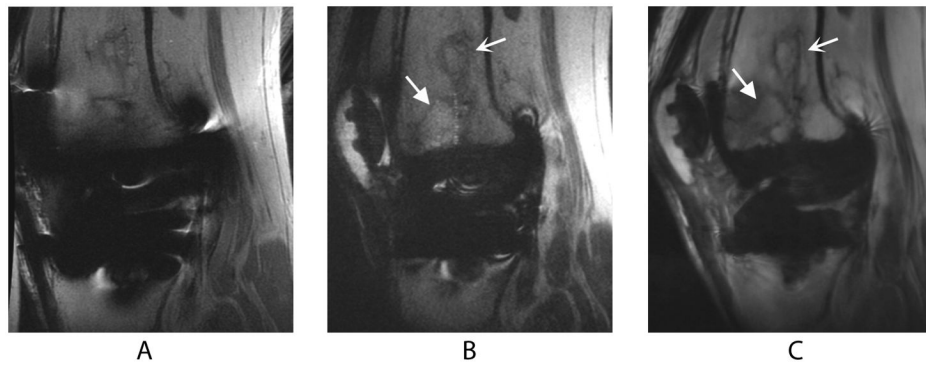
Sagittal images of a TKR produced by FSE (a), SEMAC (b), and MAVRIC (c) MRI pulse sequences in a volunteer who presented with knee pain at the time of scanning. The bone infarct (*curved arrow*) and presumed stress fracture (*wedge-shaped arrow*) are clearly seen on the SEMAC and particularly the MAVRIC images, but distortion obscures part of the fracture on the FSE image. The different apparent signal-to-noise ratios in these images can be attributed to the SEMAC image being combined using a linear, rather than a sum-of-squares, reconstruction.
